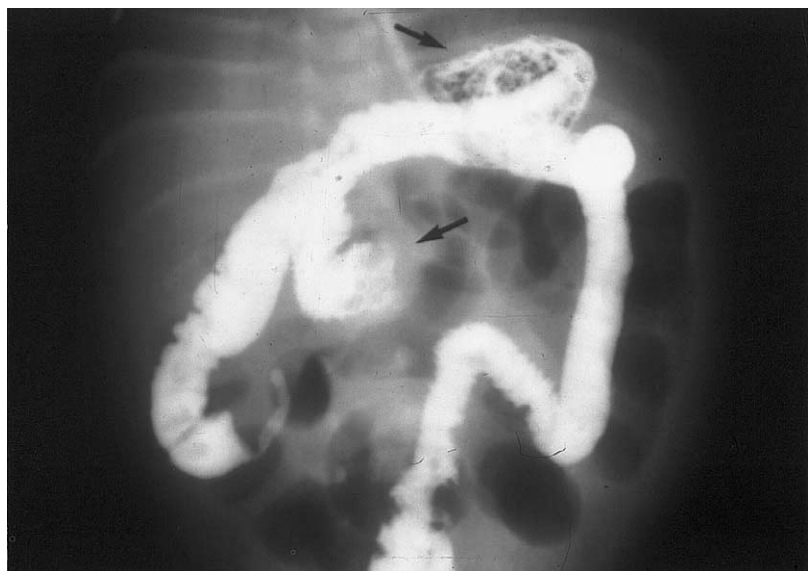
Radiograph of contrast examination of an infant with delayed presentation of bilious vomiting. The abdomen was distended and tender. Note the obstruction of stomach and duodenum (arrows), the "high" cecum on contrast enema and the gas-filled loops of small bowel. Midgut volvulus with ischemic infarction was confirmed at laparotomy.
